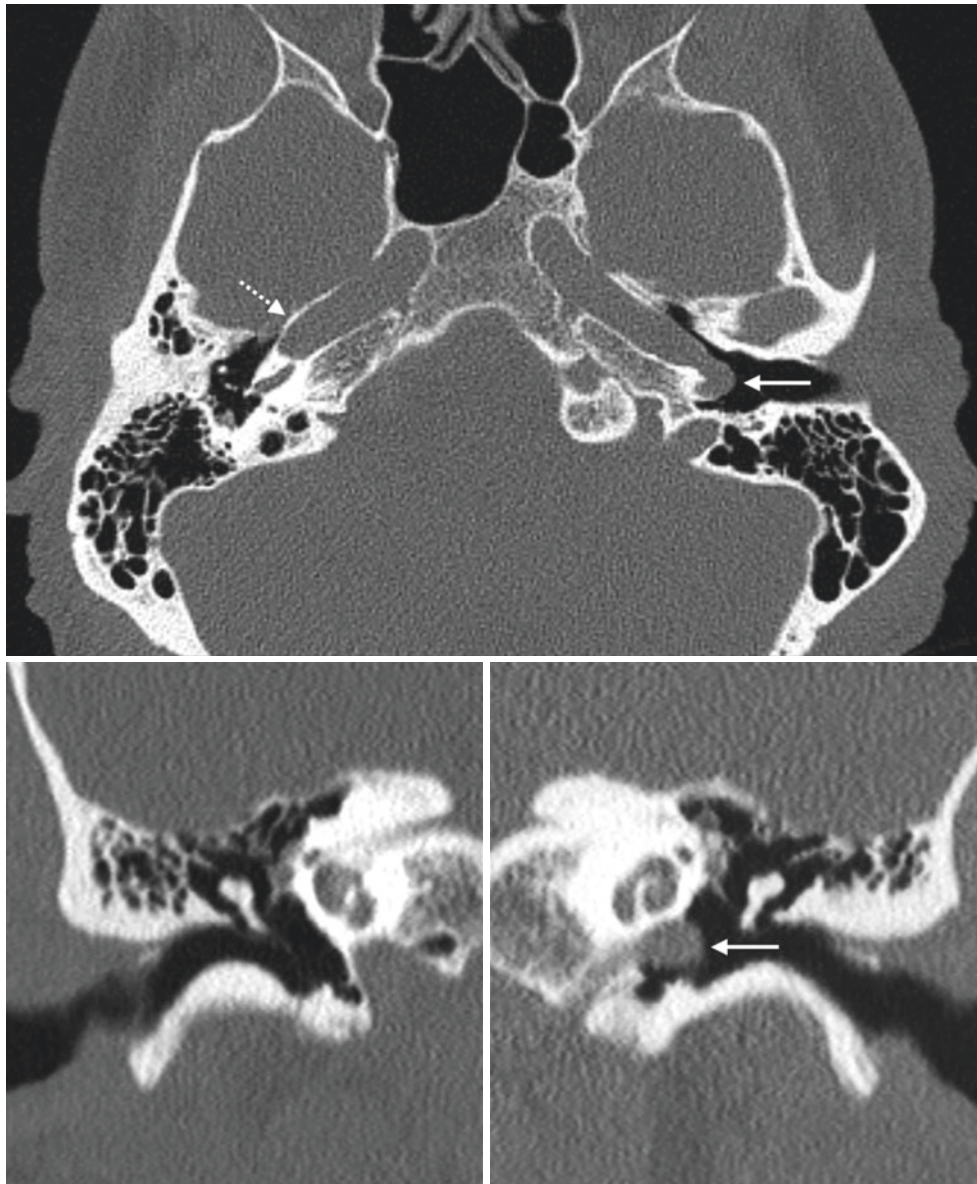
Aberrant ICA. A 48 year old male with left-sided conductive hearing loss underwent a temporal bone CT (*top*), which demonstrated a tortuous course of the small left ICA (*arrows*) overlying the cochlear promontory; this represents an aberrant ICA. Note the right
